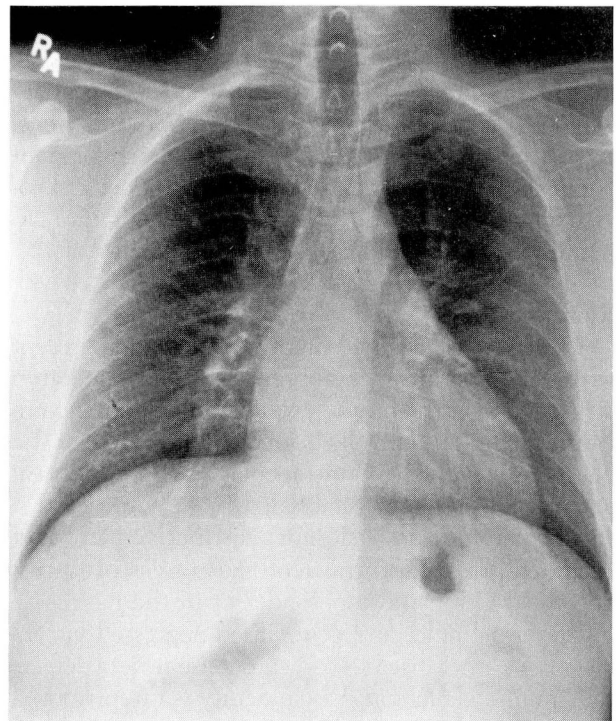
Chest roentgenogram and computed tomographic scan of a 45-year-old man with chest discomfort.
